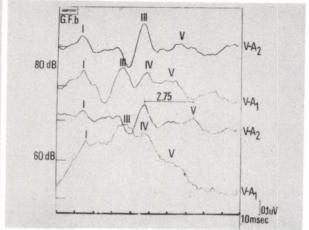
BAEP at the beginning and CT 1 year later in a 1.5-year-old child with craniospinal astrocytoma V-A2: right side: I.-V. IPL near the upper limit, and the IILD is increased
